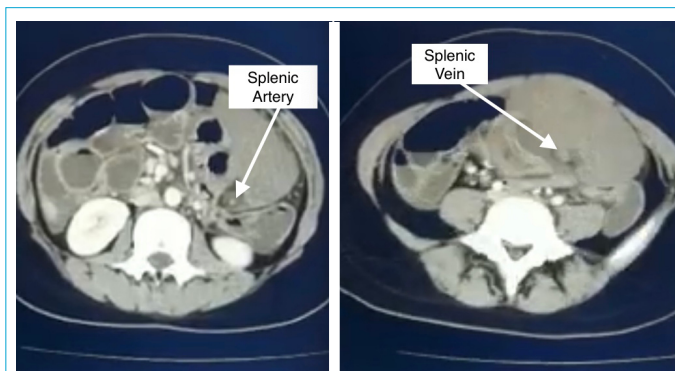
Intravenous contrast abdominal Computed tomography view of splenic torsion and splenic vessels.
